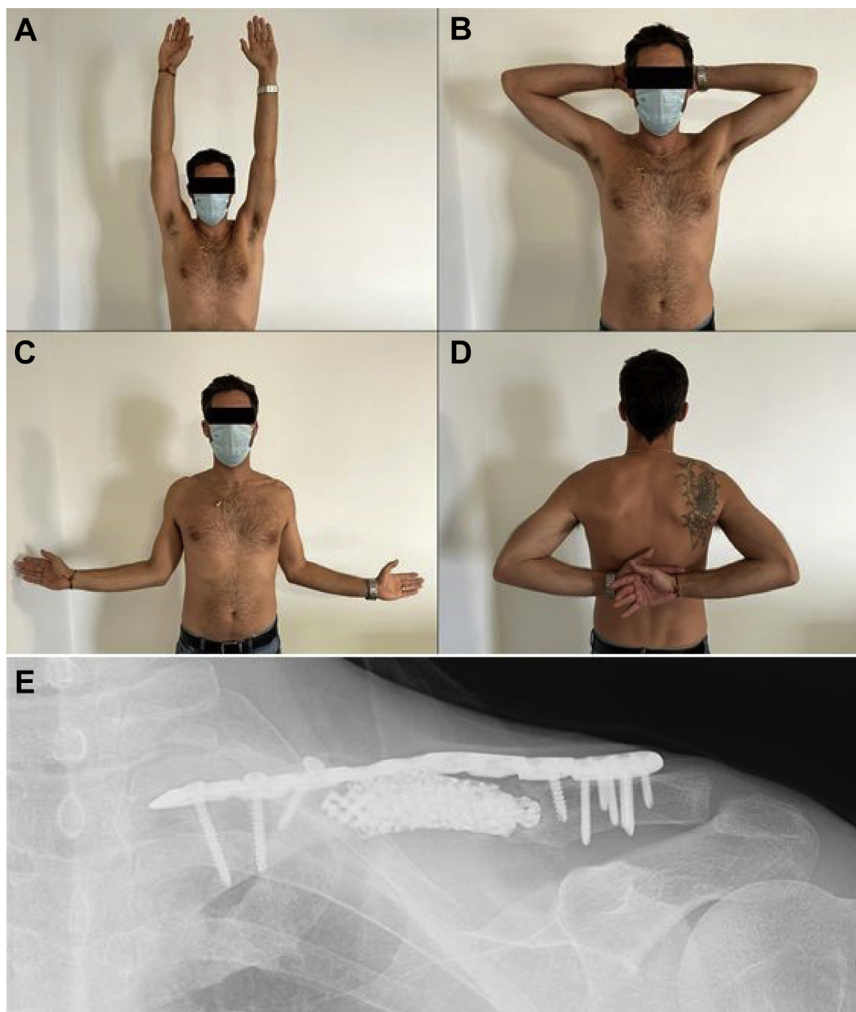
(A–D) Two years after surgery, the patient had a complete range of motion of the left shoulder. (E) The follow-up x-ray 2 years after surgery.
